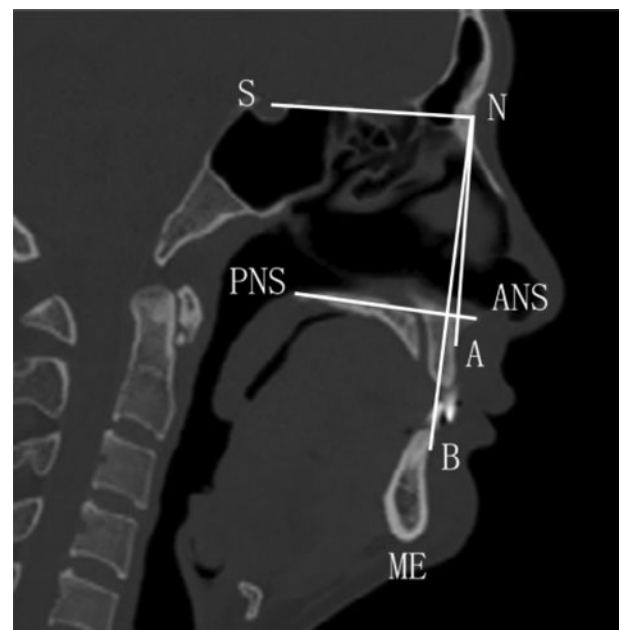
Sagittal computed tomography scan showing a graphical representation of landmarks, reference lines and angle parameters. Landmarks include: subspinale (A); supramentale (B); sella (S), at the centre of the pituitary fossa; nasion (N); anterior nasal spine (ANS); posterior nasal spine (PNS); and menton (ME). Reference line: 'ANS-PNS', reflecting the sagittal dimension of the maxilla. Angle parameters include: anteroposterior position of the maxilla relative to the anterior cranial base (S–N–A); anteroposterior position of the mandible relative to the anterior cranial base (S–N–B); and anteroposterior relation of the maxilla and the mandible (A–N–B).
